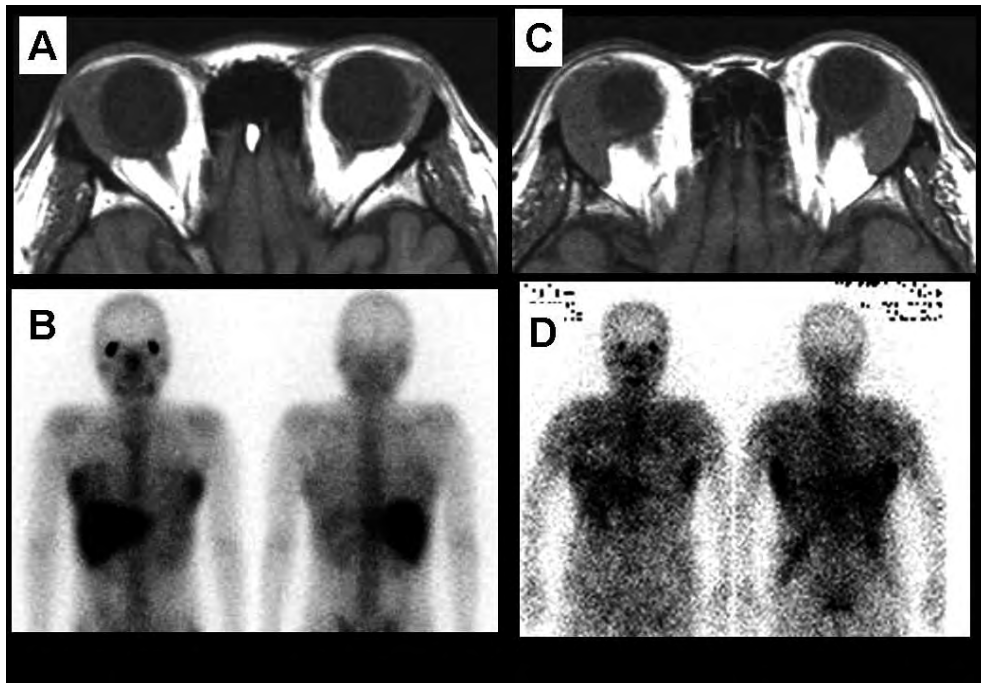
Case 1 (left column) and Case 9 (right column). A 21-year-old woman (Case 1) presents bilateral lacrimal gland masses on T1-weighted magnetic resonance imaging (5A) in the 4-year-course of IgA nephropathy. Gallium scan shows abnormal uptake only in the bilateral lacrimal glands (5B). A 60-year-old woman (Case 9) presents bilateral lacrimal gland masses on T1-weighted magnetic resonance imaging (5C) and abnormal gallium scan uptake not only in the bilateral lacrimal glands but also in the body areas corresponding to systemic lymphadenopathy (5D).
